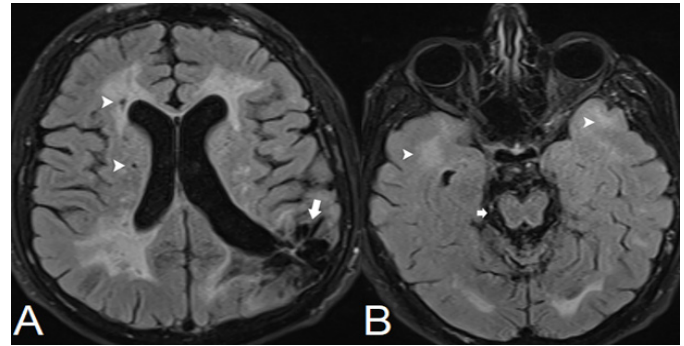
Brain MRI of Case 1. Axial FLAIR images. A. Symmetrical confluent hyperintense signal changes in the periventricular and the subcortical white matter and lacunar infarctions (arrowheads). Hypointense signal change indicating gliotic area due to previous lobar hemorrhage in the left parietal lobe (arrow). B. Hyperintense signal changes in the anterior temporal lobes (arrowheads) and brainstem atrophy (arrow).
